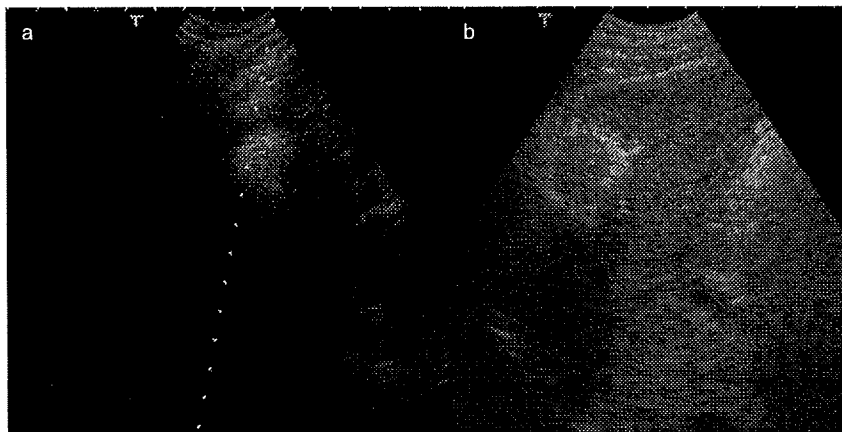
Hyperechoic change on conventional ultrasonography. (a) A hyperechoic area appeared immediately after radiofrequency ablation. (b) Five minutes after radiofrequency ablation, the hyperechoic rim is seen on ultrasonography.
